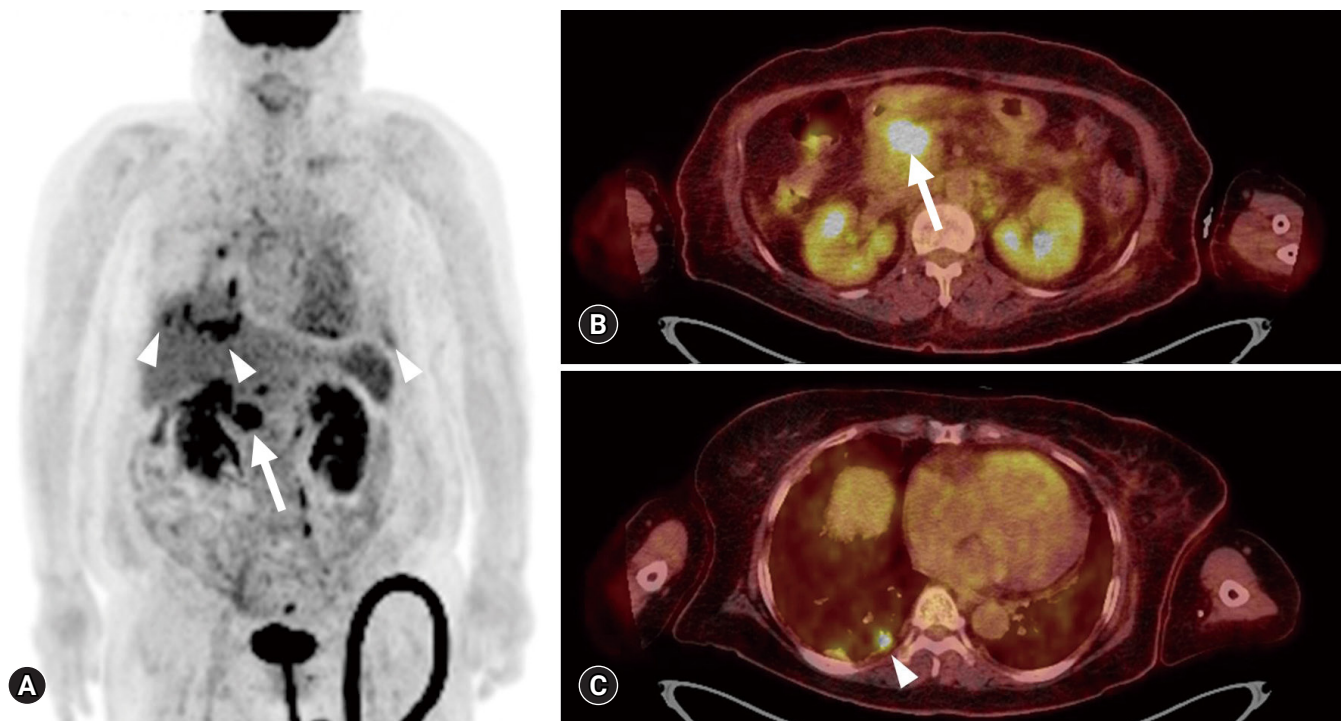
^{18}F -2-fluoro-2-deoxy-D-glucose-positron emission tomography integrated with computed tomography. Maximum intensity projection image (A) and fusion axial views (B, C) show a hypermetabolic mass at the pancreatic head and neck region (arrow) with systemic lymph nodes, bilateral lung and both pleural metastases (arrowhead).
